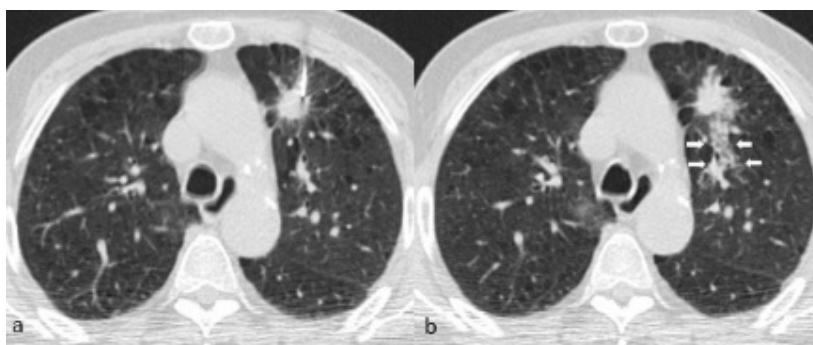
(a,b) Pneumothorax (black arrow) occurred after a CT-TTNB to the lesion in right upper lobeFigure 2. (a,b) Hemorrhage (white arrow) posterior to lesion the in left upper lobe after a CT-TTNB
